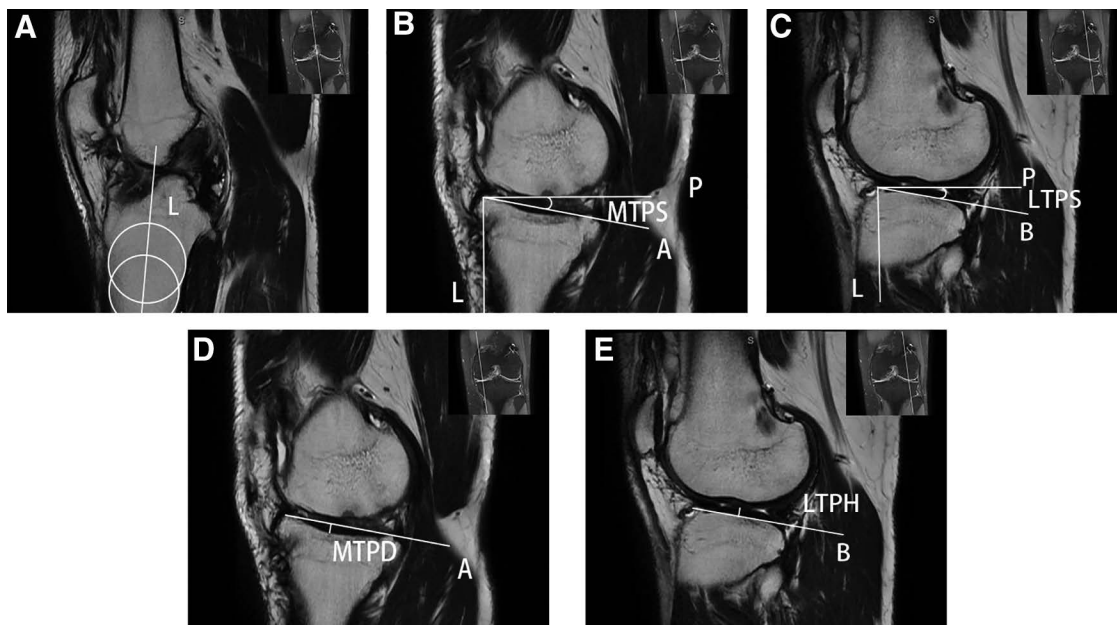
MRI parameters measured for evaluation of the proximal tibia morphology. (A) The way to locate the longitudinal tibial axis. (B–E) Measurements of the MTPS, LTPS, MTPD, and LTPH. LTPH = lateral tibial plateau height, LTPS = lateral tibial posterior slope, MRI = magnetic resonance imaging, MTPD = medial tibial plateau depth, MTPS = medial tibial posterior slope.
